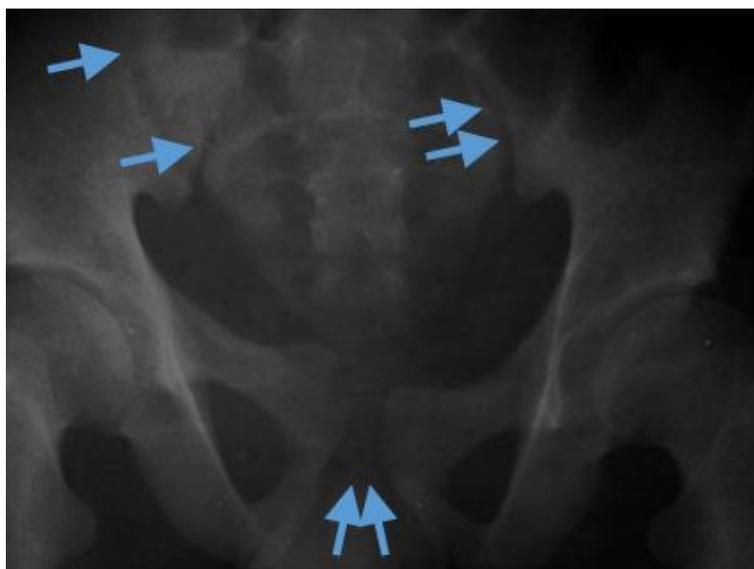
Plain x-ray of the Pelvis. AP View showing Bilateral sacroiliac joints (anterior and posterior) and pubic symphysis diastases (horizontal arrows) and minimal asymmetry of the pubic bones (arrowheads) indicating Vertical shear fracture
